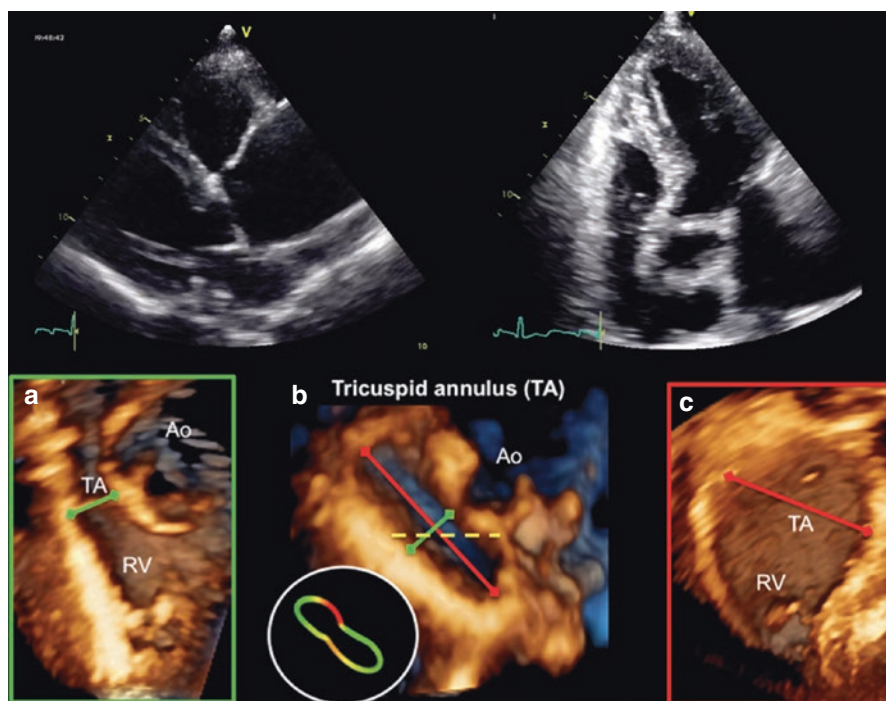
Tricuspid annulus deformation due to extrinsic compression by dilated and tortuous ascending aorta demonstrated by 3D echocardiography, as the most likely cause of valve incompetency in a patient presenting with “idiopathic” tricuspid regurgitation. (a) minimal tricuspid annulus diameter (green); (b) en face view of tricuspid annulus, showing maximal (red) and minimal (green) diameters, as well as the 4-chamber diameter (yellow); (c) maximal tricuspid annulus diameter (red)
